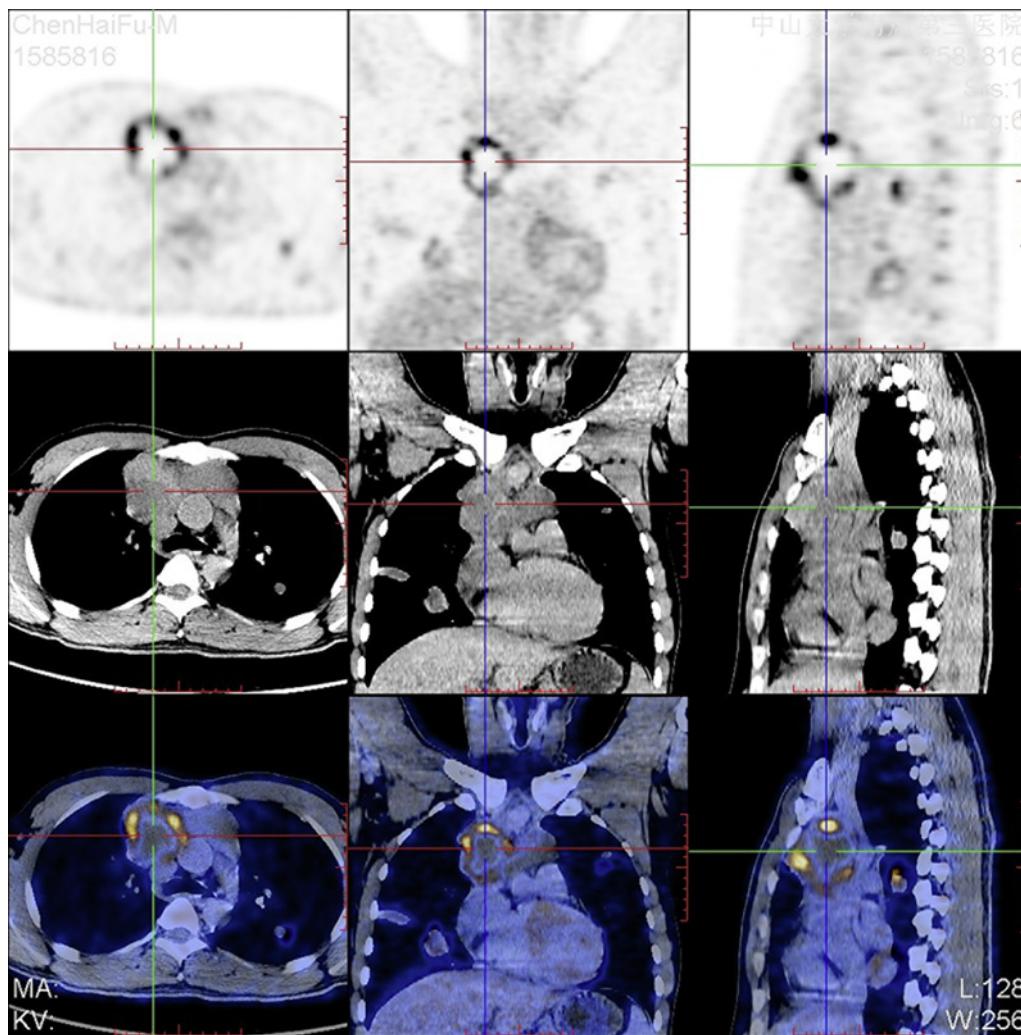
PET-CT revealed solid-appearing mass on the right side of anterior superior mediastinum, extending to pleura and pericardium, whose metabolic activity was classified as malignant. PET-CT, positron emission tomography-computed tomography.
